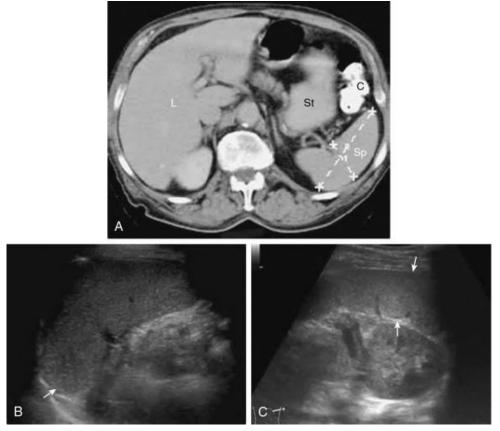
A, Transverse CT image of the upper left quadrant demonstrates the posterior position of the spleen. Sp, spleen; L, liver; St, stomach; and C, colon.Transverse image (B) and longitudinal image (C) of the spleen with measurements.
